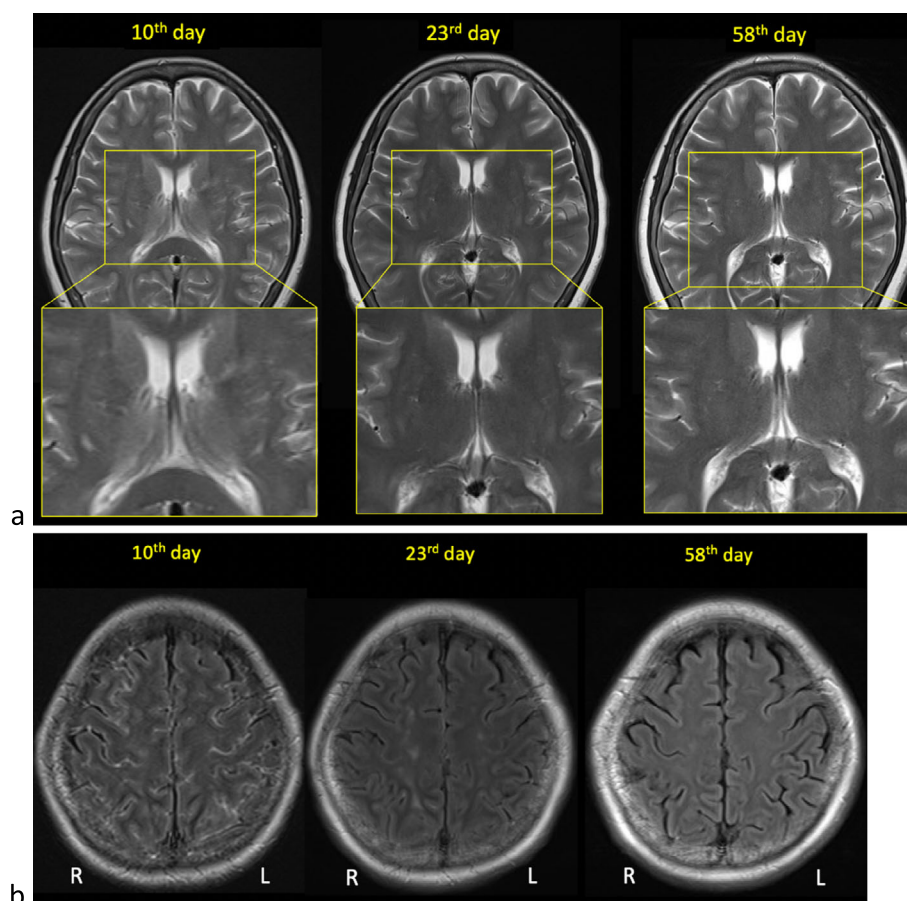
MRI findings after MTX withdrawal. a) The subcortical high signal and periventricular linear high signal in the lateral ventricles seen on post-contrast T2-weighted MRI are improved. b) The subarachnoid pattern seen on post-contrast FLAIR MRI is improved. L: left, MRI: magnetic resonance imaging, MTX: methotrexate, R: right, FLAIR: fluid attenuated inversion recovery
